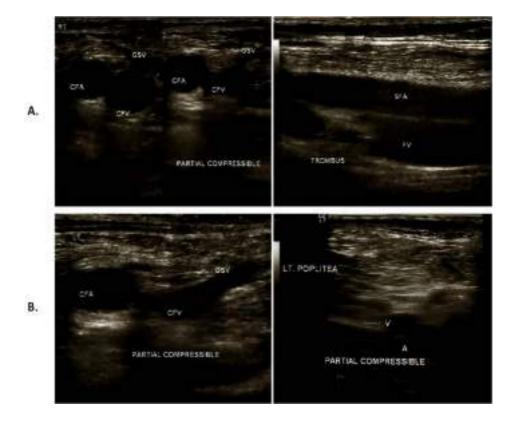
Doppler ultrasound examination of the patient supported the Deep Vein Thrombosis (DVT) image. Thrombus was found from the level of the common femoral vein of the right lower extremity (A) and from the common femoral vein and popliteal vein of the left lower extremity (B).
